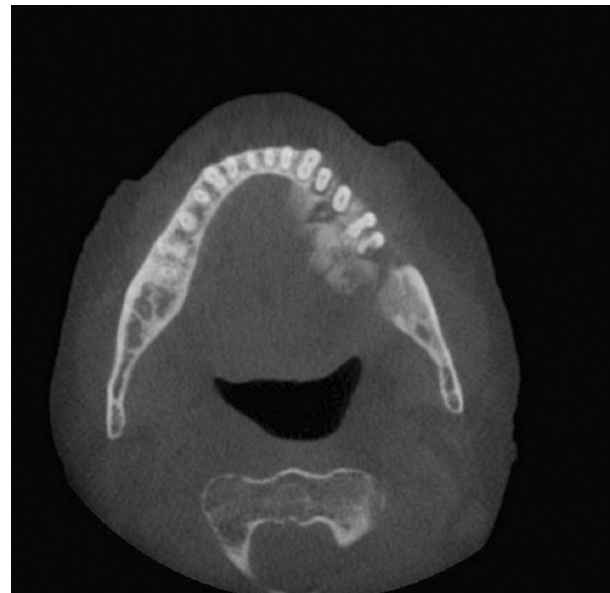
An axial view of the cone beam CT mandible revealing the expansile mass in the left mandible.
